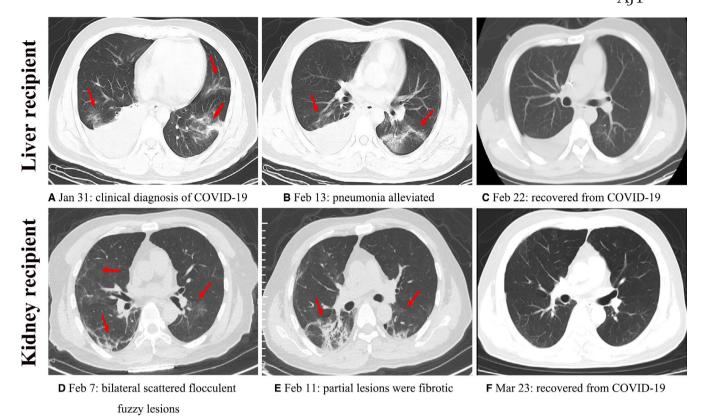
Changes in chest CT scan of these two COVID-19-positive SOT recipients during hospitalization. A-C: pulmonary imaging of liver transplant recipient; D-F: pulmonary imaging of renal transplant recipient [Color figure can be viewed at wileyonlinelibrary.com]
